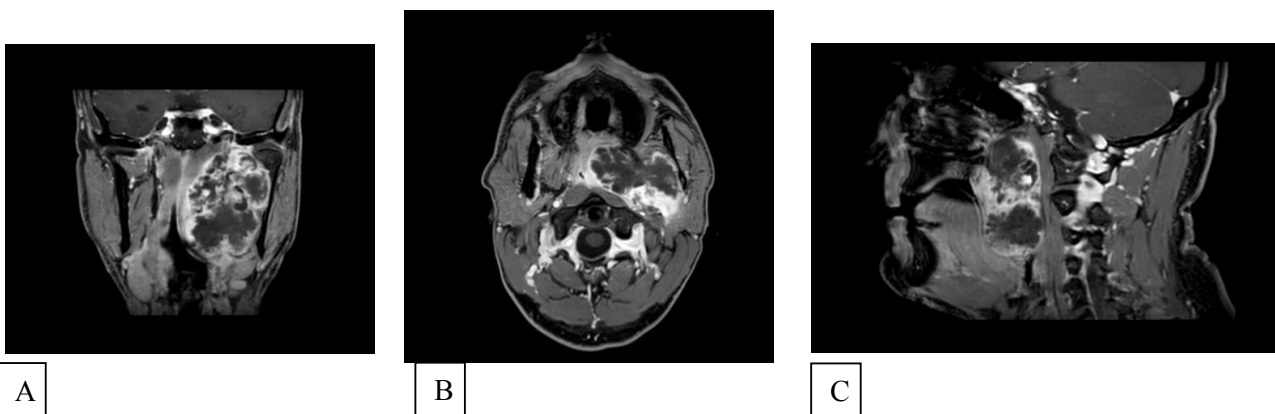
MRI. A) coronal plane; B) axial plane; C) sagittal plane.
